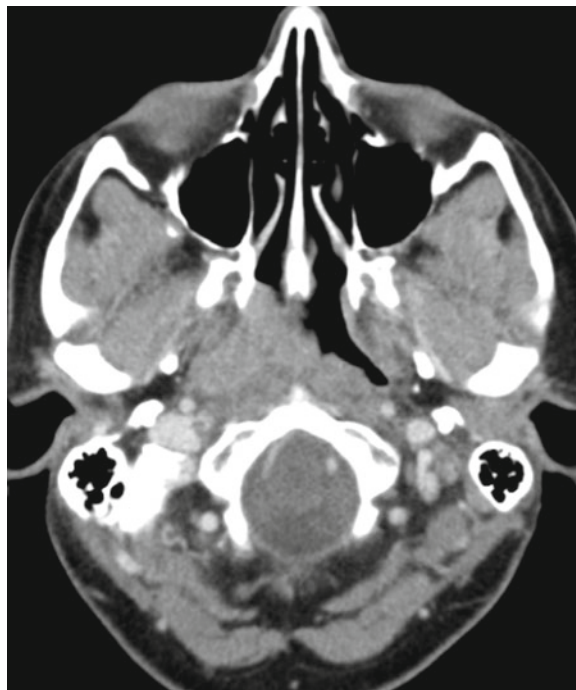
Axial MRI shows the typical primary tumor of NPC (T3) extending into the right infratemporal fossa
